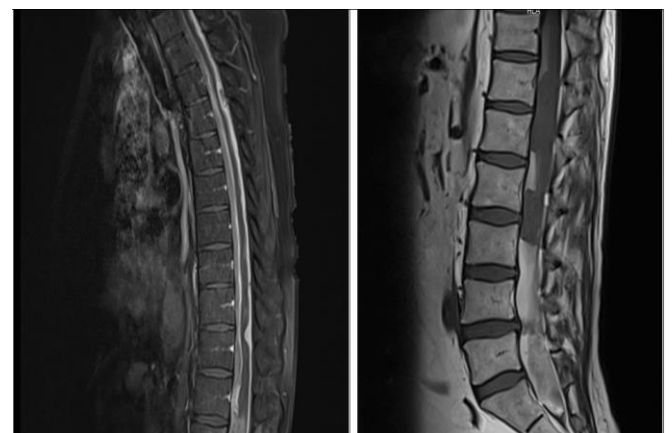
MRI THORACIC-LUMBAR: Multiple intra-dural metastatic mass lesions are observed in the thoracic and lumbar regions, which compress the spinal cord. In addition, there are diffuse linear enhancement and millimetric nodular metastases along the spinal cord.
